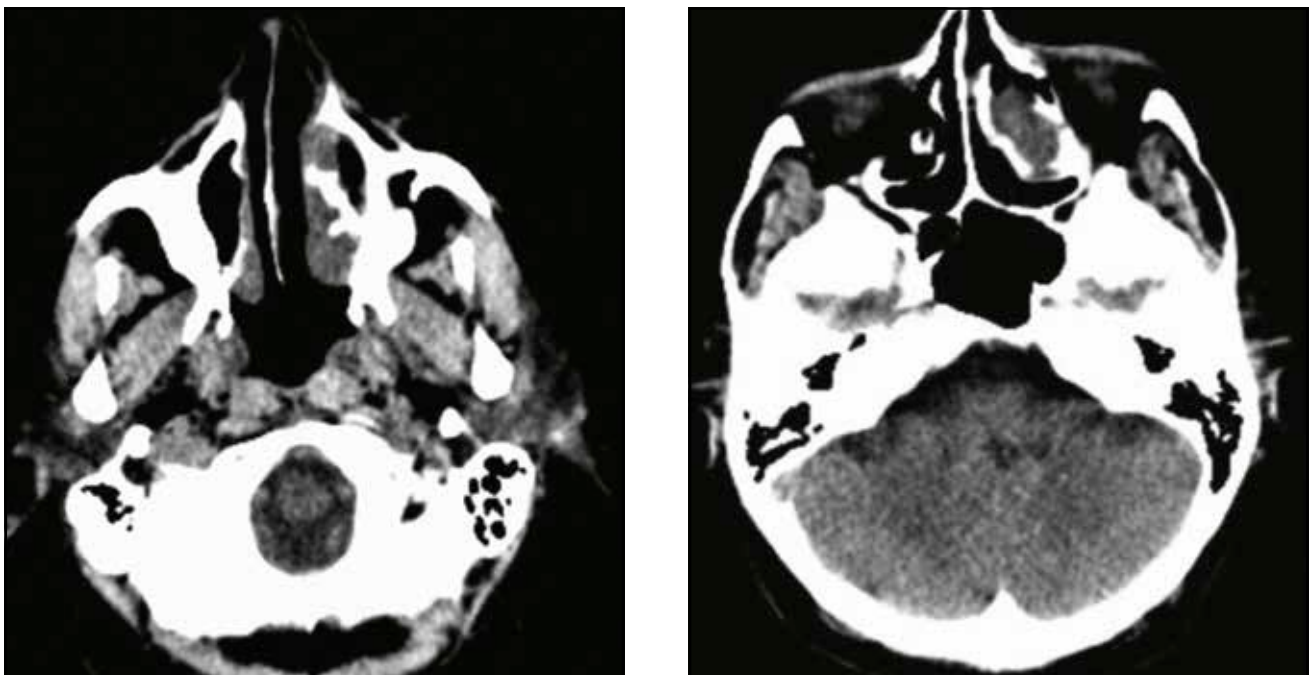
Cranial CT scan, contrast-enhanced (axial slices) – the tumor completely occupies the left ethmoidal sinus, extended to the nasal cavity and left orbit; hypodense content in the left sphenoid and maxillary sinuses (hypoplastic).
